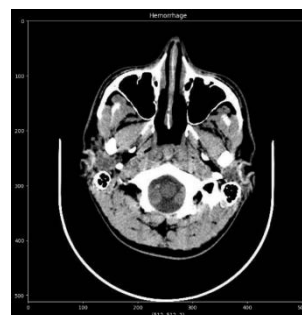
Hemorrhage Brain MRI
